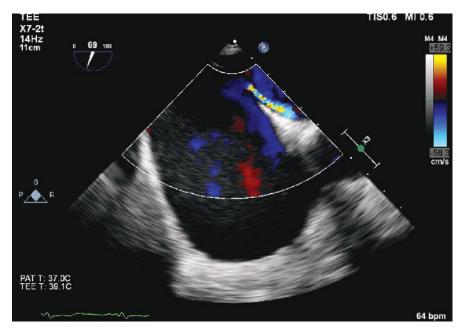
Transesophageal echocardiogram showing a dilated right atrium and patent foramen ovale with continuous shunting.
